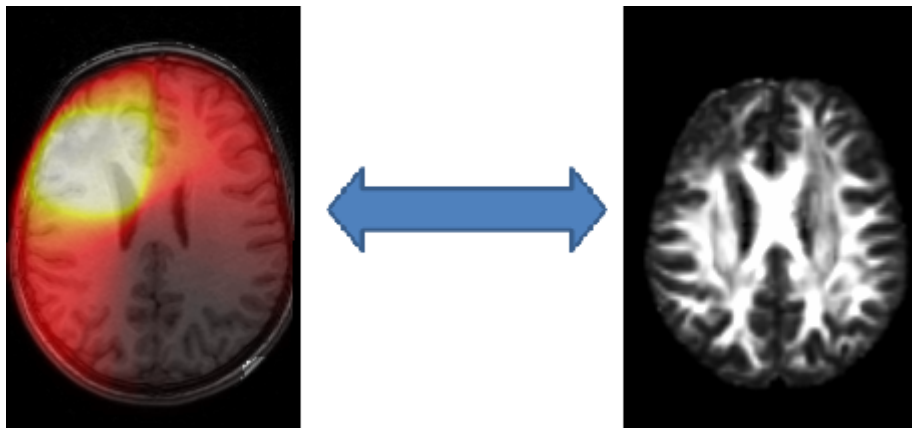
Left: MRI acquisition with integrated the information of radiation dose of a pediatric patient. Right: Fractional Anisotropy of the same patient.
